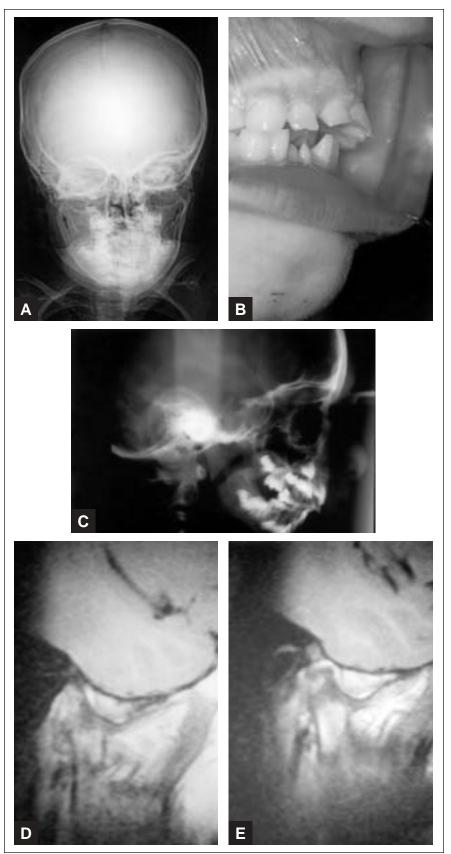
Bilateral late stage (stage 3) TMJ derangements in 9-year-old boy with progressive worsening retrognathia, anterior open bite, functional limitation in mouth movements and bilateral joint clicking A, Postero-anterior cephalometric radiograph showing a bilateral TMJ fractures and the medial dislocation of the condyles (arrows). B, Intraoral view showing the anterior open bite. C, Lateral cephalometric radiograph showing retrognathia and open bite, D, Closed-mouth images of right TMJ reveal anterior displacement and degeneration of the meniscus and a deformed condyle E, views of opposite (left) joint (both joints imaged simultaneously) reveal a deformed condyle.
